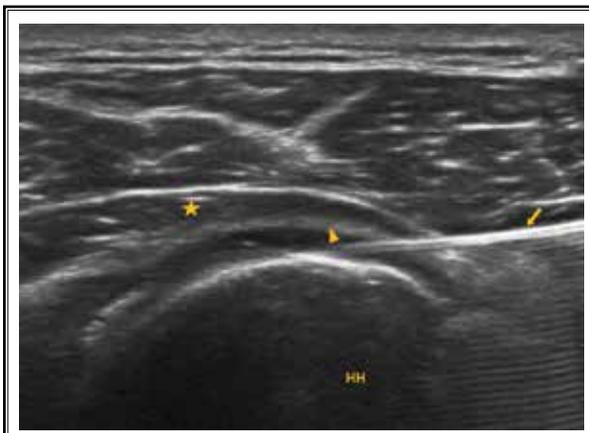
Transverse ultrasound view of the PC approach injection. The needle tip (arrow) is positioned in the PC (arrow head) of GH joint under the infraspinatus tendon (asterisk).
